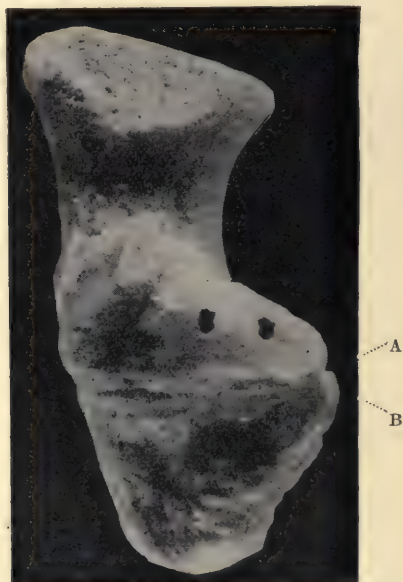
PHOTOGRAPH OF OS CALCIS FROM A CASE OF CONGENITAL VARUS IN ADULT (UPPER ASPECT). (No. 3,510, St. Bartholomew's Hospital Museum.)
